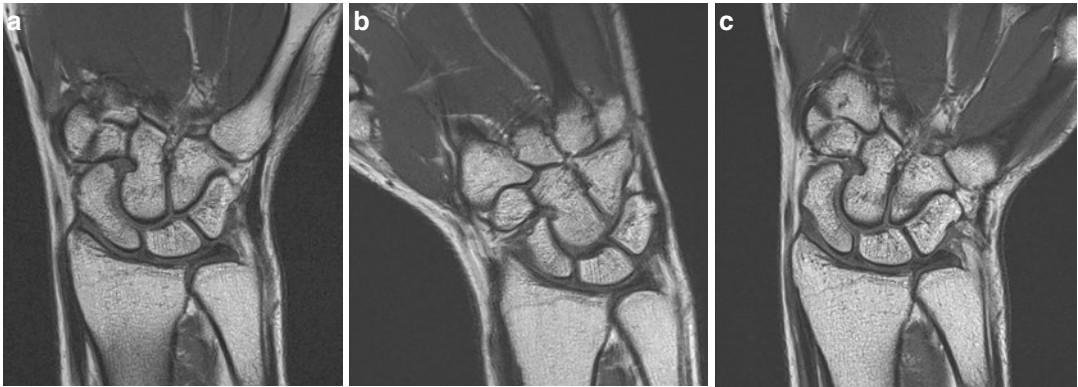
Coronal T1 MR images. Relationship between the radius and lunate in neutral (a), radial tilt (b), and ulnar tilt (c). Note that the lunate locates completely in the lunate notch of the radius in (c)
